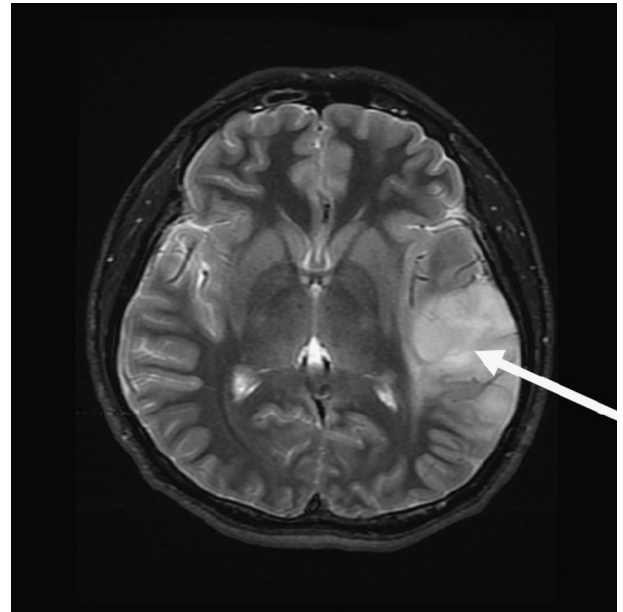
Axial T2-weighted magnetic resonance image (MRI) shows a round hyperintense tumor with perifocal edema in the left temporal lobe (arrow).
